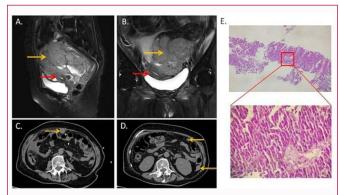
A) Pelvic nuclear magnetic sagittal view of uterine atrophy surrounded with solid mass shadow. Yellow arrow indicates tumor, whereas right arrow indicates uterine. B) Pelvic nuclear magnetic coronal position to visualize atrophy of the left uterine surrounded with solid mass shadow. C, D) Multiple peritoneal metastases were identified in PET-CT scan. E) Pathologic diagnosis of the patient showing malignant tumor cells. The magnification of the top image was 10x, and the bottom image was 40x.
